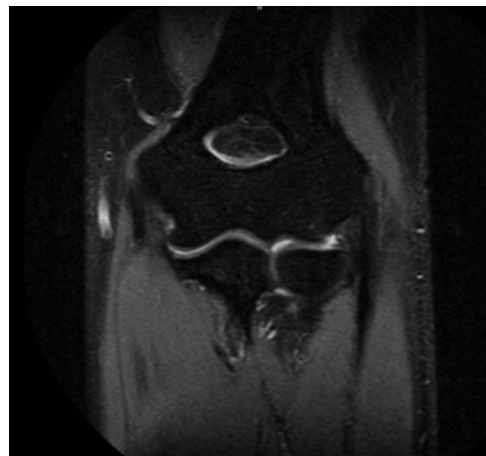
A coronal fat-suppressed T2-weighted MRI at 7-wk-follow-up showing complete healing of the insertion of the extensor carpi radialis brevis (ECRB) in Patient 5.
